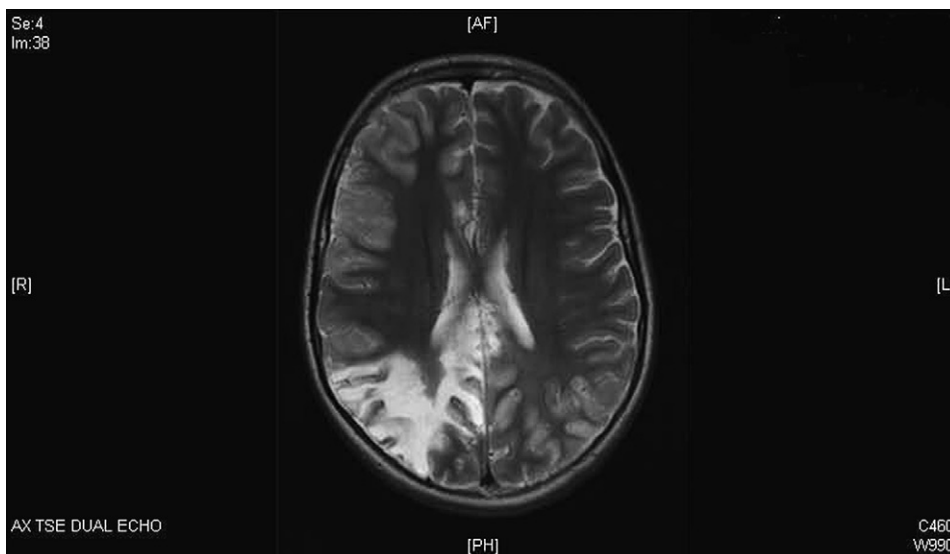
MRI shows necrotizing encephalitis affecting the right parietal and temporal lobes, patient 3.
